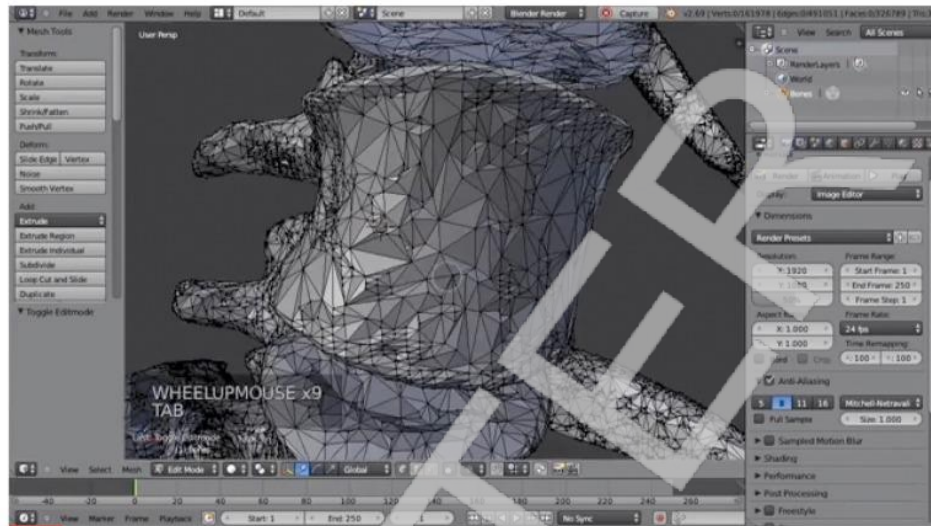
Radiographic images can be converted to 3D print files to create complex, customized anatomical and medical structures.¹²
